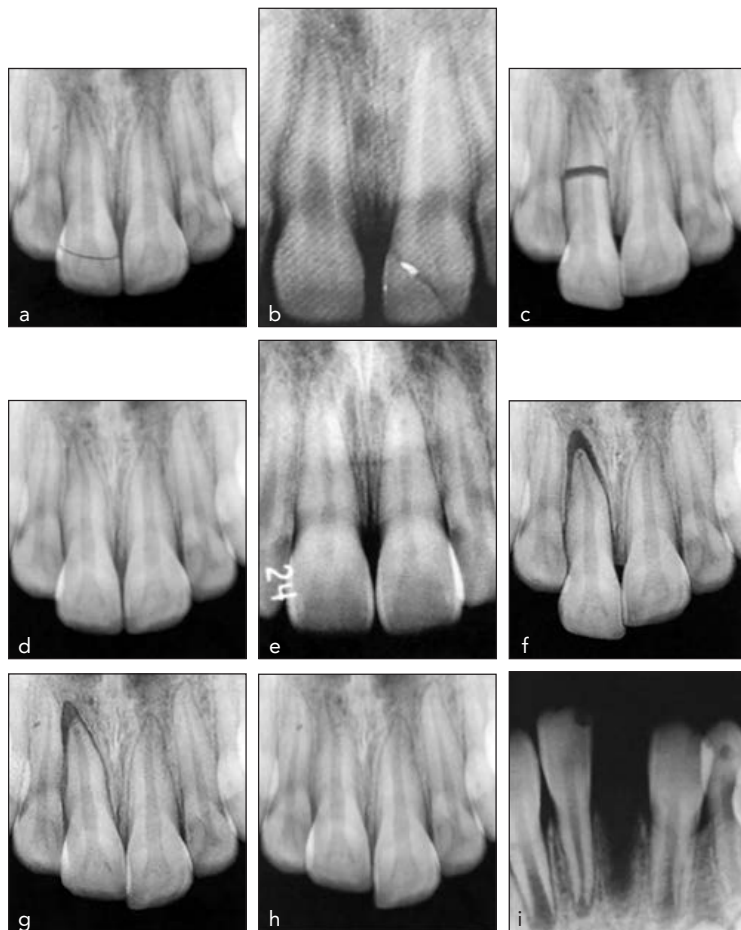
Radiographic presentations of traumatic dental injuries. (a) Uncomplicated crown fracture. (b) Complicated crown fracture. (c) Horizontal root fracture. (d) Concussion. (e) Subluxation. (f) Extrusive luxation. (g) Lateral luxation. (h) Intrusive luxation. (i) Avulsion.
